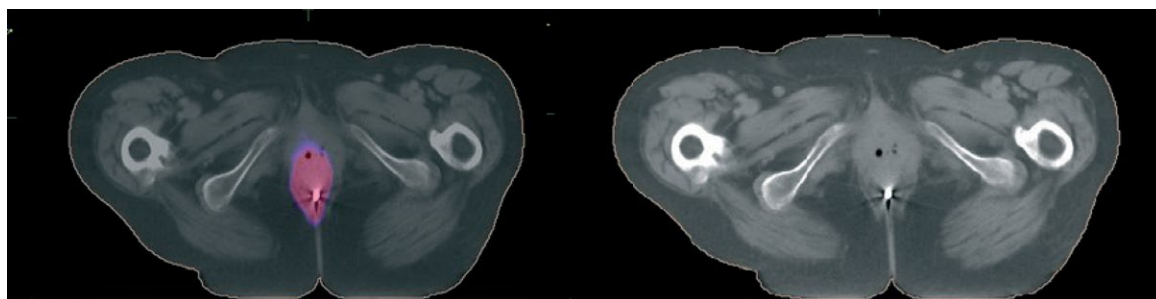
In this figure, we can see the difference in the data of primary tumor only of anal canal between FDG PET and CT. On the left side of the figure is image fusion PET-CT and on the right only CT imaging
